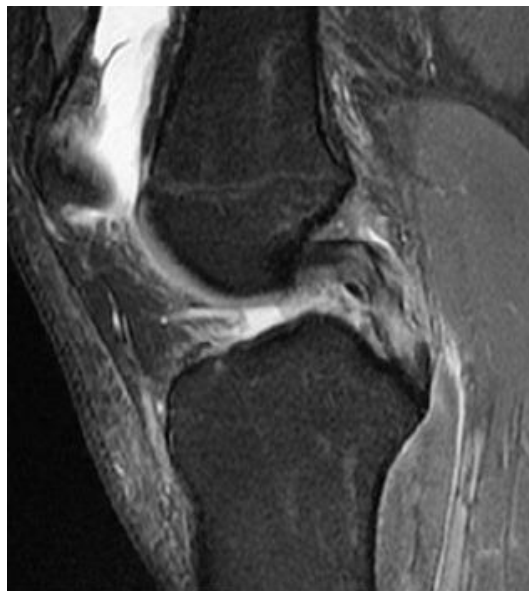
Sagittal MRI image shows a partial tear in the posterior cruciate ligament.
